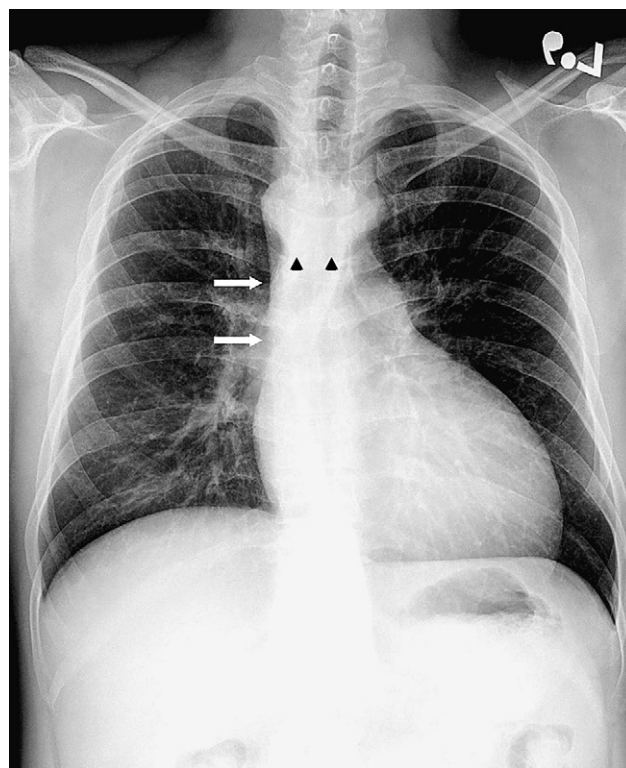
Chest radiography showed right-sided aorta (white arrows) and an upper mediastinal mass (black arrowheads).
